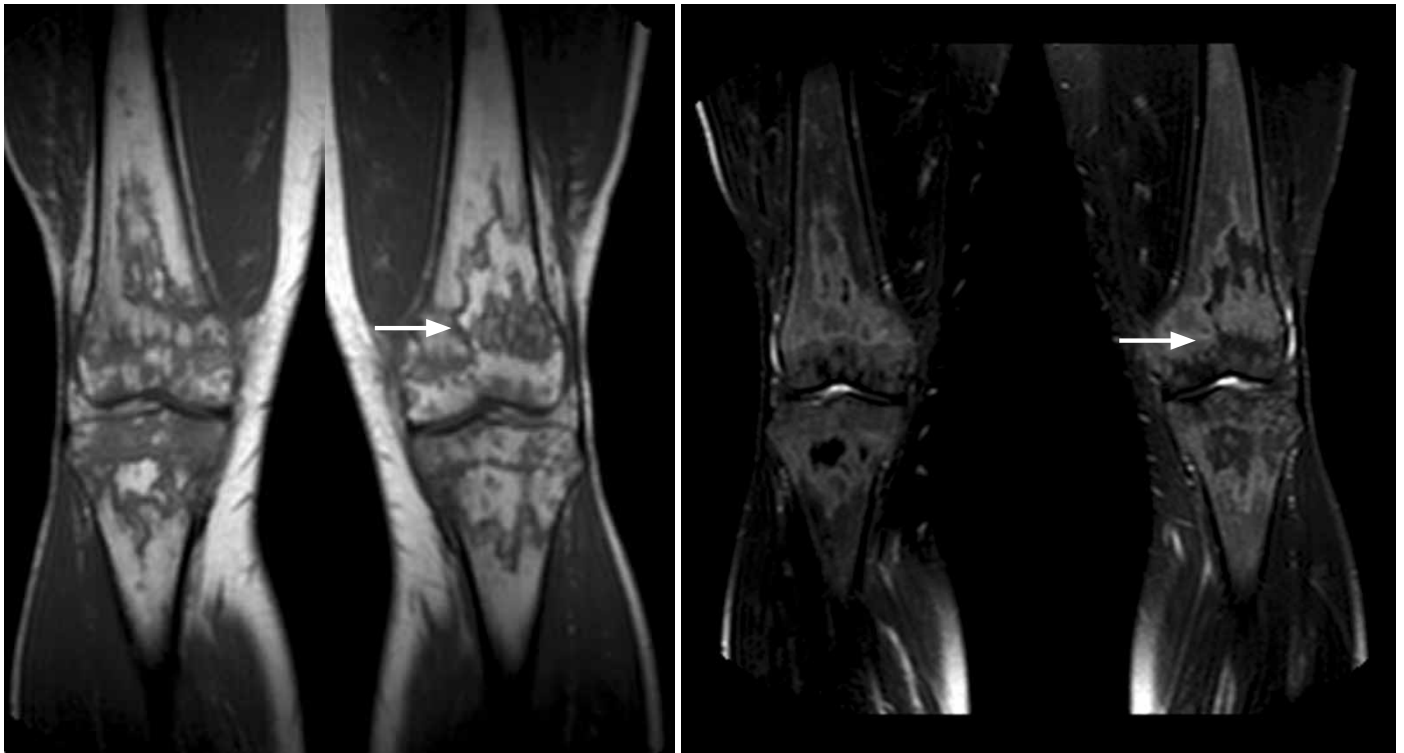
MRI examination of both knees was performed on the same day as the radiographic examination. The left images are T1 weighted, and the right images are T2 weighted with chemical fat suppression. There were extensive abnormalities in the bone marrow, with well-demarcated foci of intermediate-to-low T1 signal and high T2 signal within the fatty marrow. These geographic areas of abnormal signal are typical of bone infarctions. Multiple lesions were present, involving all bones of the knees. The arrows denotes one of these presumed bone infarctions in the left femoral metaphyseal region.
